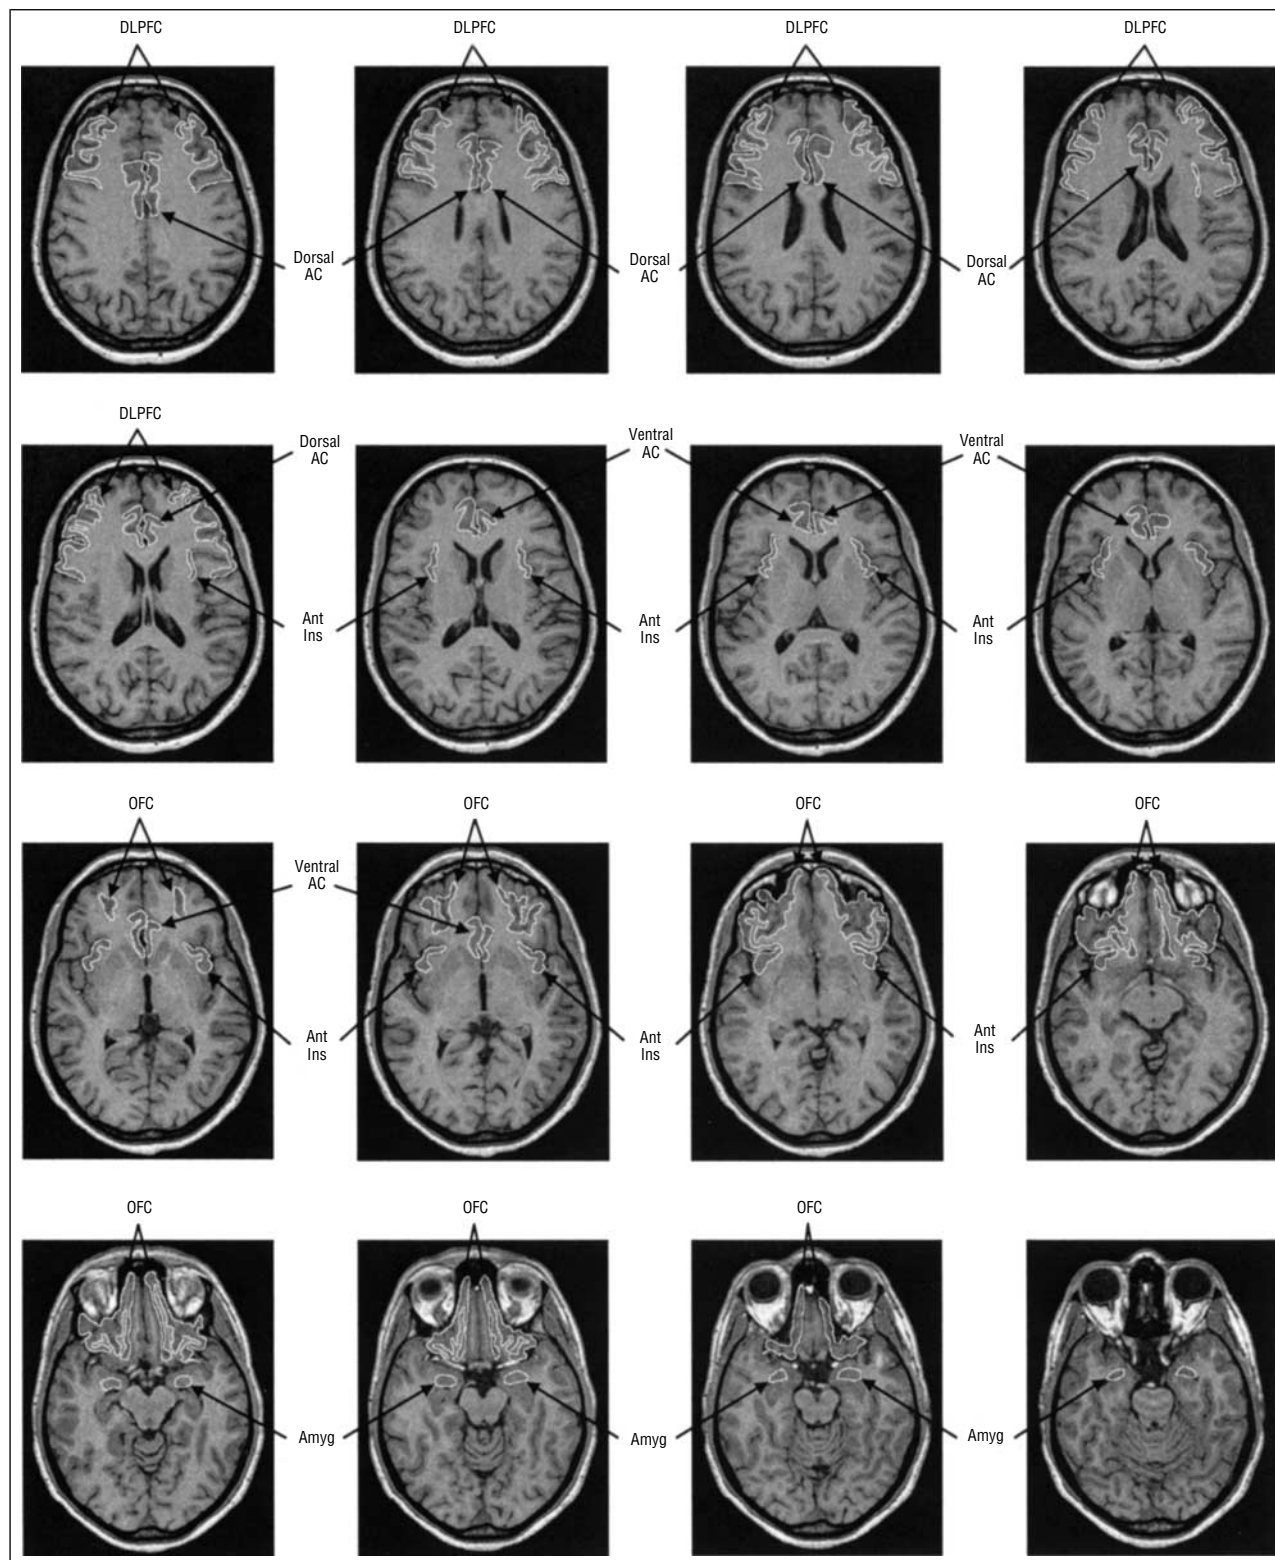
Regions of interest drawn on a magnetic resonance image of a study subject for transfer onto coregistered positron emission tomography scans. Images are presented from dorsal (top) to ventral (bottom). DLPFC indicates dorsolateral prefrontal cortex; AC, anterior cingulate gyrus; Ant Ins, anterior insula; OFC, orbitofrontal cortex; and Amyg, amygdala.
